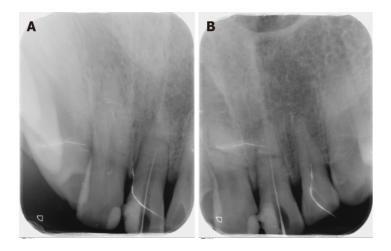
Periapical radiographs. A: Periapical radiograph showing the file at the fracture line; B: Periapical radiograph for determining the working length.
